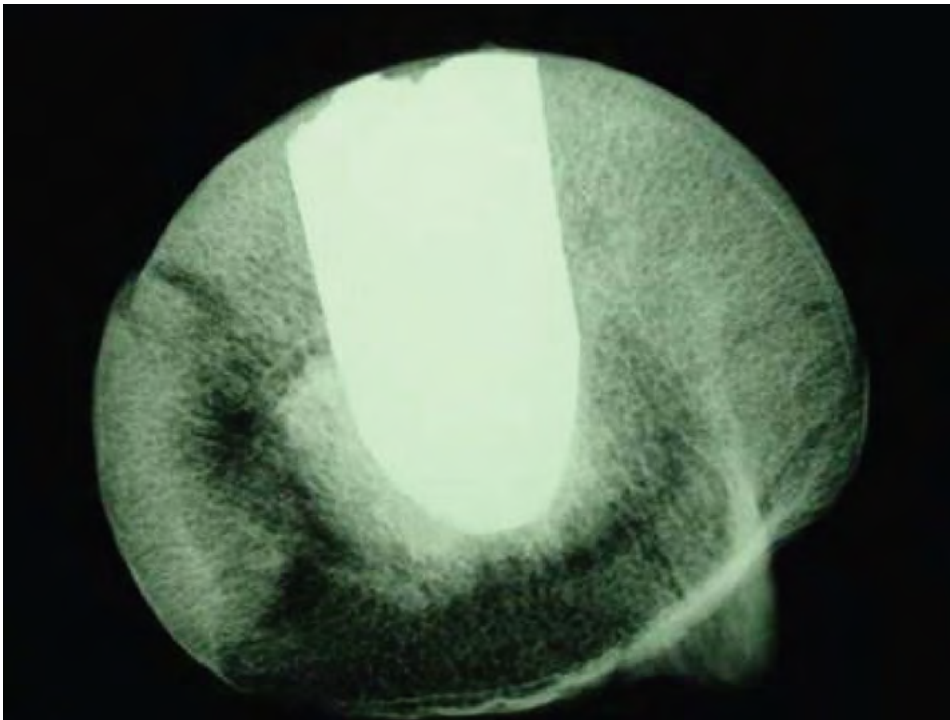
Radiograph of femoral head (ID 786; anterior view)
